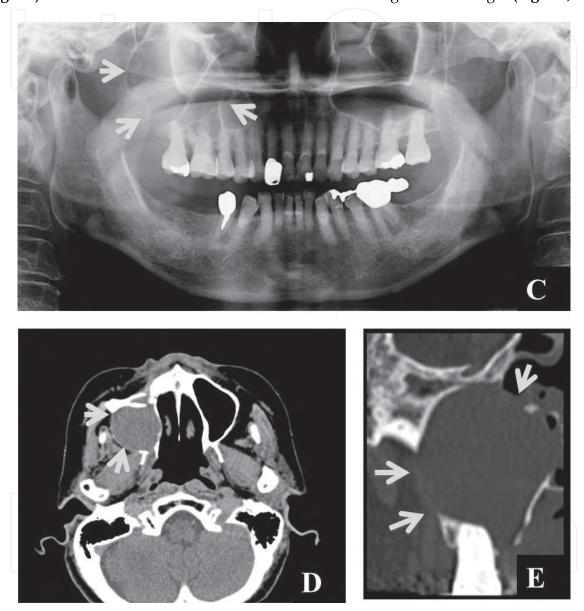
Panoramic radiograph images (A, C), axial CT images (B, D), oblique coronal CT image (E) of a postoperative maxillary cyst in the right sinus region (arrows).
